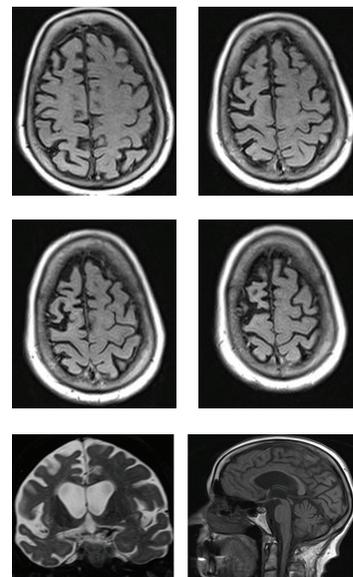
Axial, T2-weighted and fluid-attenuated inversion recovery (FLAIR), MRI images of the brain, demonstrating asymmetric cortical atrophy in the right hemisphere of the patient.
